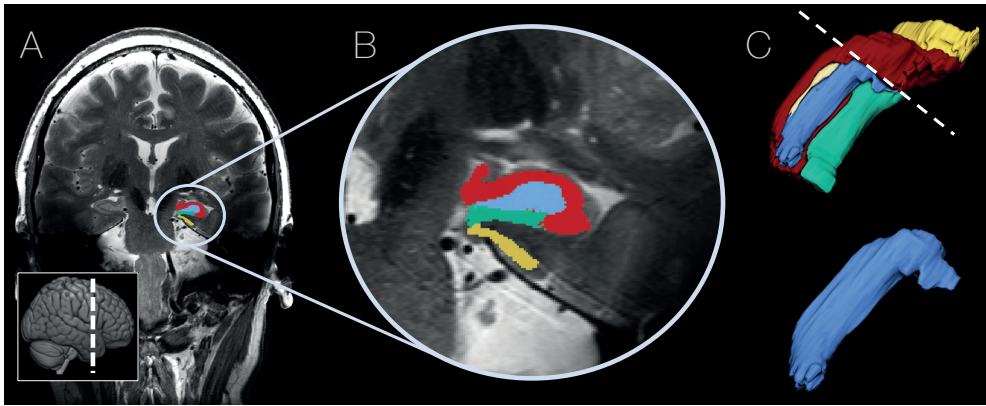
Hippocampal subfield (left) segmentation and 3D rendering of the hippocampus and dentate gyrus. Panel (a) displays a whole brain T2-weighted scan showing the location of the hippocampus in a coronal slice. The location of the slice is presented in the left corner of the figure. Panel (b) displays the hippocampus subfield segmentation at the same position as panel (a) and is color coded: red = CA1; blue = DG; turquoise = subiculum, and desert = ERC. Panel (c) displays a 3D rendering of the hippocampus (upper) and the DG (lower). The dashed white line shows the positioning of the 3D hippocampus relative to panel (b). The same color coding as panel (b) is used for panel (c)
